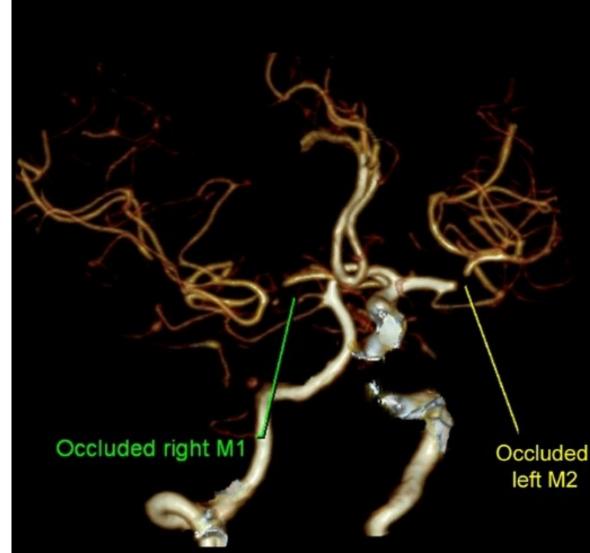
Brain CT performed 3 hours after symptom onset showing the persistence of the right occlusion and a new left M1 and M2 occlusion
